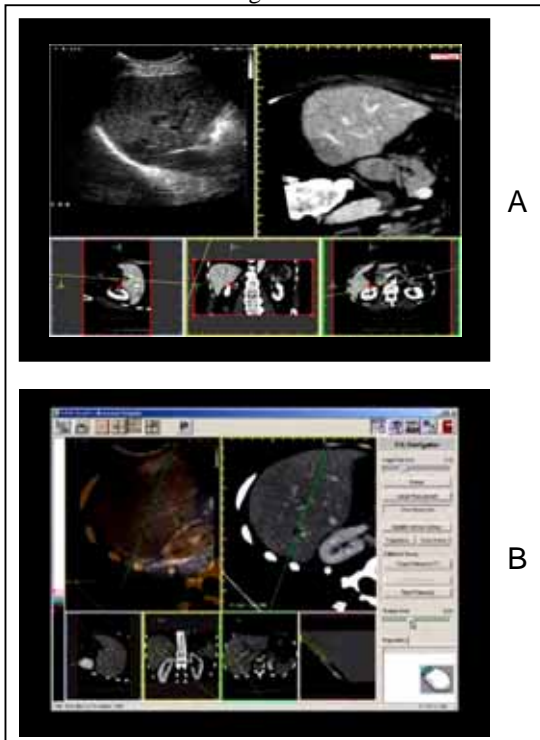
A) Patient Navigation exam B) with CT/US overlap
